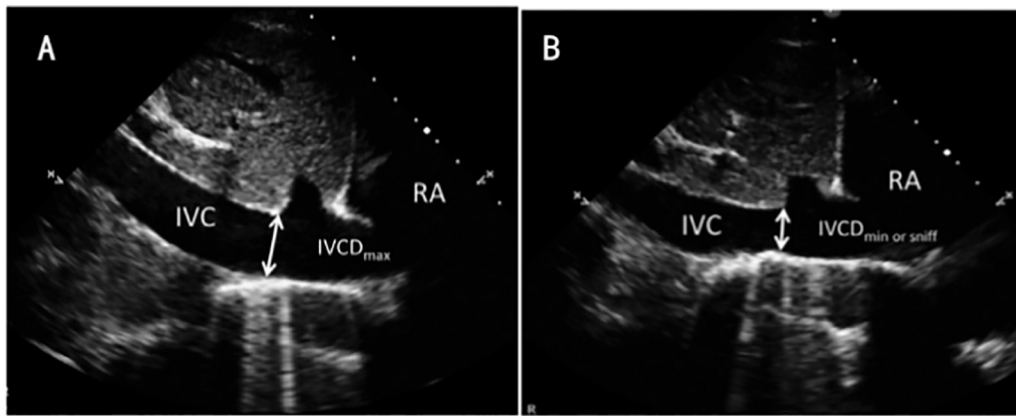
Cross-sectional echocardiograms of the IVC in the subcostal long-axis view at end-expiration (A) and during inspiration with or without sniff (B). RAP was estimated by the respirophasic variation of the inferior vena cava diameter (IVCD) [30].
